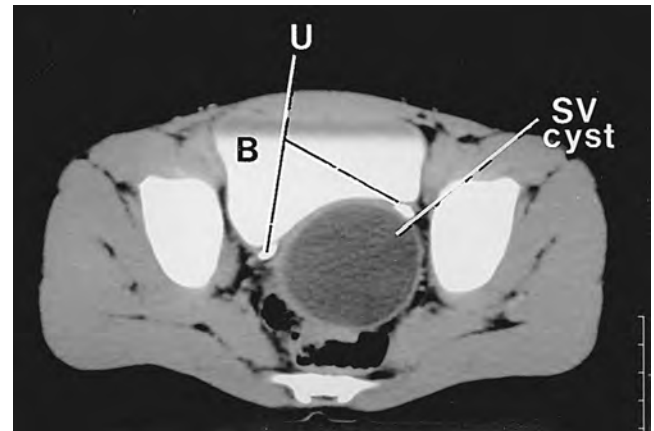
Computed tomography scan of seminal vesicle (SV) cyst. B, bladder; U, ureters.
